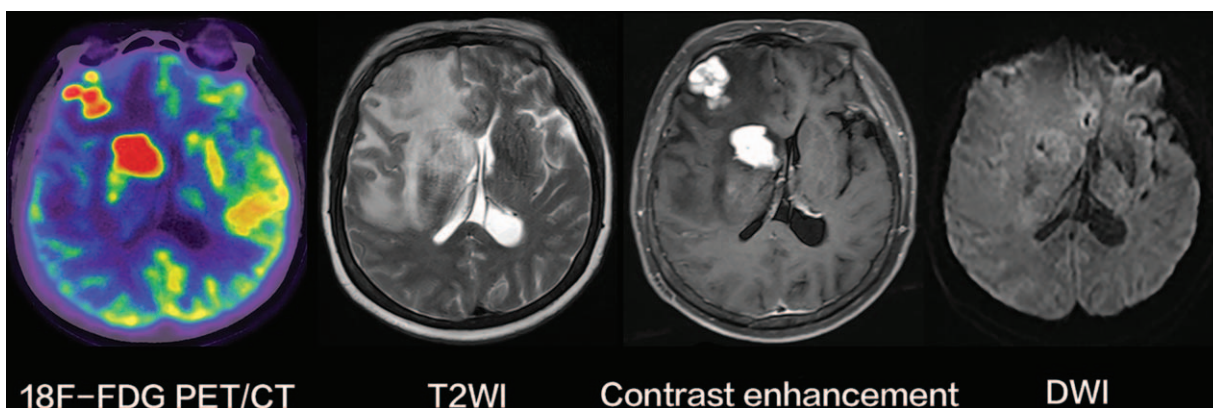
Multiple diffuse large B-cell lymphomas. Two lesions in the right frontal lobe and basal ganglion exhibited much higher accumulation of ¹⁸F-FDG on PET images than normal gray matter. They exhibited iso to hyperintensities with edema on T2-weighted MR images, strong and relatively homogeneous enhancement on contrast-enhanced T1-weighted MR images, and slightly restricted diffusion on diffusion-weighted MR images.
